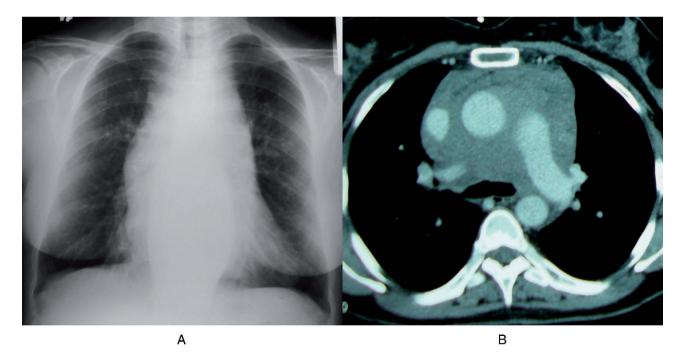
Chest radiograph, where a mediastinal enlargement can be observed (A), and thoracic computed tomography showing an infiltrating mass around the vascular and mediastinal structures (B).
